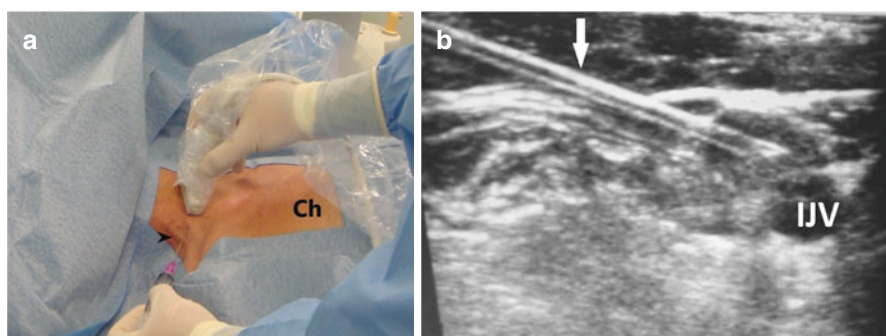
Posterior puncture of the internal jugular vein. (a) Needle introduced between external jugular vein (arrow head) and sternocleidomastoid muscle; Ch—patient's chest; (b) corresponding ultrasound image; IJV—internal jugular vein; white arrow—puncture needle
